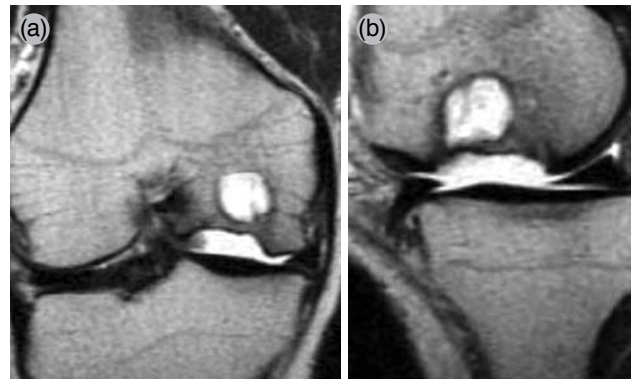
(a, b) Magnetic resonance imagings showing large bony defect due to osteochondritis dissecans with large subchondral bone cyst of right medial femoral condyle.
